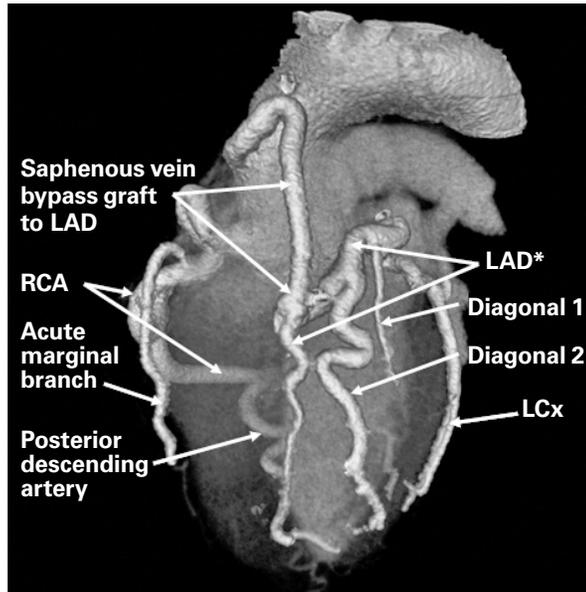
Volume-rendering of a 64-slice computed tomographic scan shows a widely patent saphenous vein graft between the mid-ascending aorta and the mid-left anterior descending artery* (LAD). The graft provides retrograde blood flow to the proximal LAD and its branches, and to the left circumflex artery (LCx). The right coronary artery (RCA) is dominant: rather large in caliber and tortuous throughout its course. The RCA supplies a medium-sized acute marginal branch and continues distally as a large posterior descending artery.
